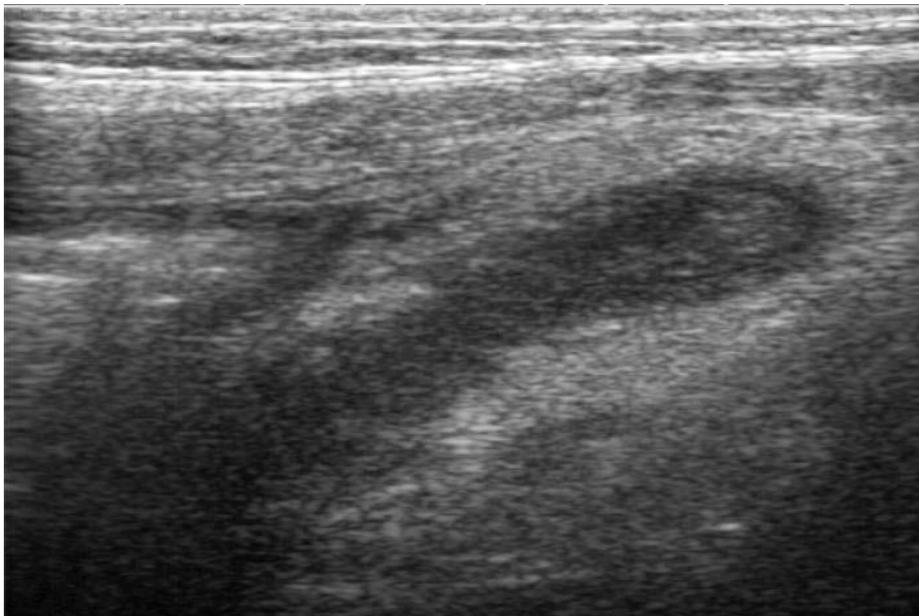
Ultrasonographic longitudinal image of a gangrenous appendicitis.
